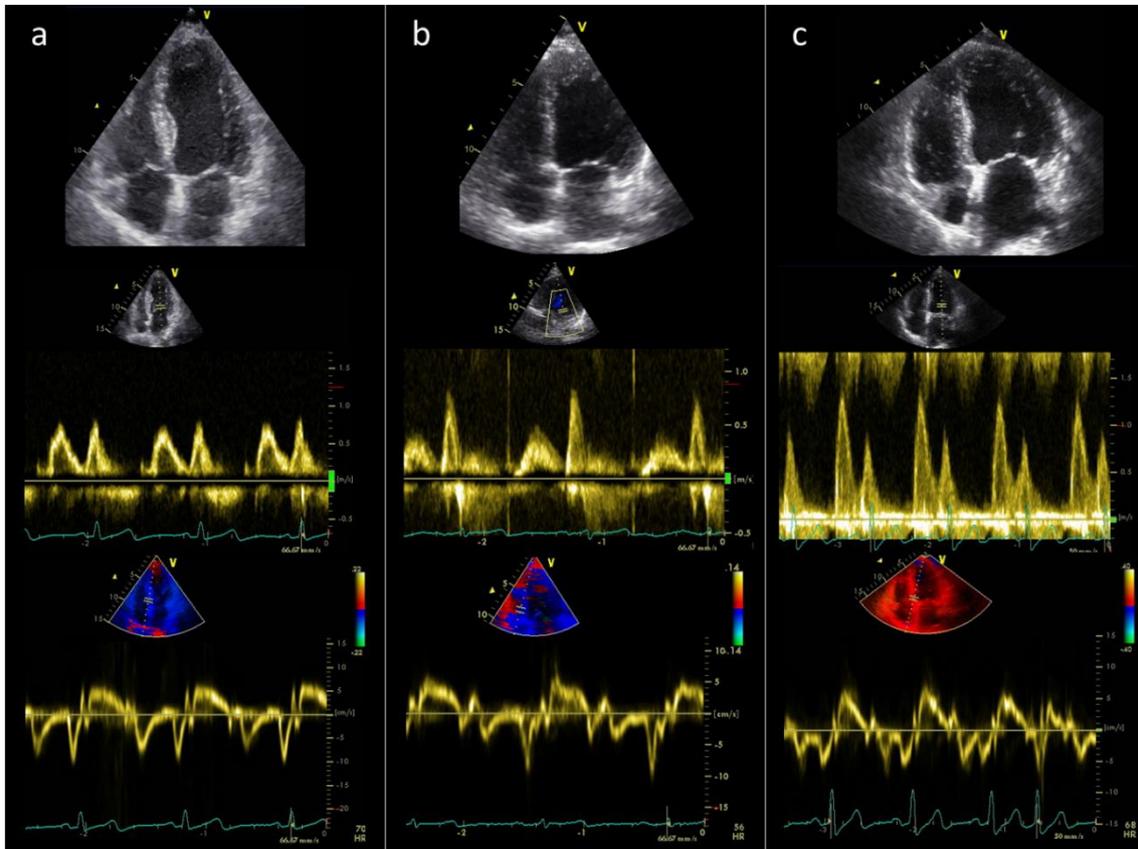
Echocardiographic assessment of cardiac remodeling and diastolic dysfunction in three exemplary female ESKD patients with preserved ejection fraction
